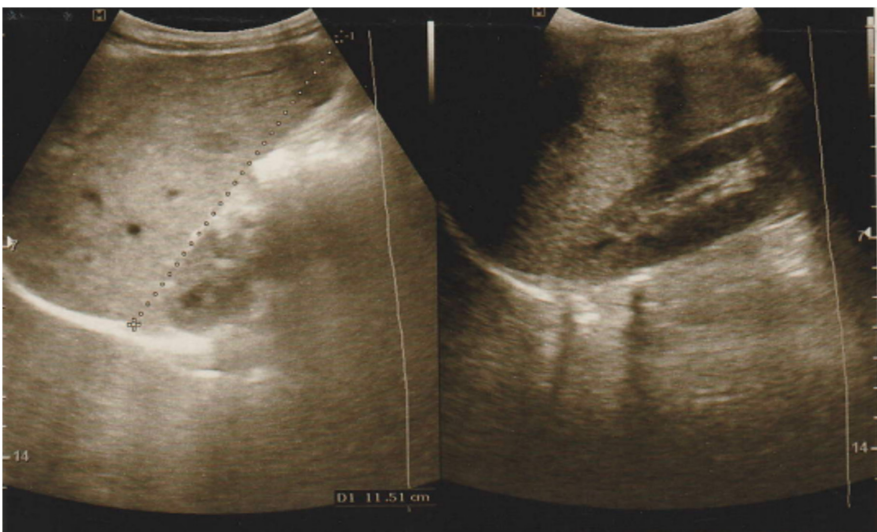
Abdominal ultrasound revealed no stones or biliary sludge in gallbladder.
